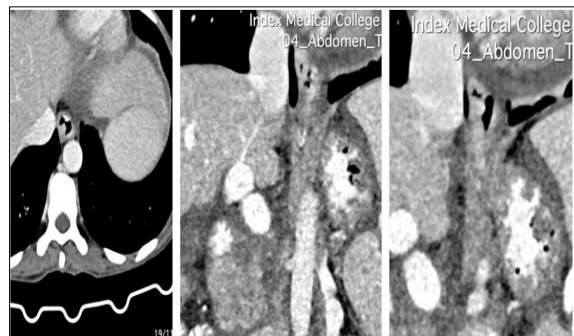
54-year-old man with cirrhosis and grade 3 esophageal varices. CT images in both axial and coronal planes varices with nearly circumferential involvement
